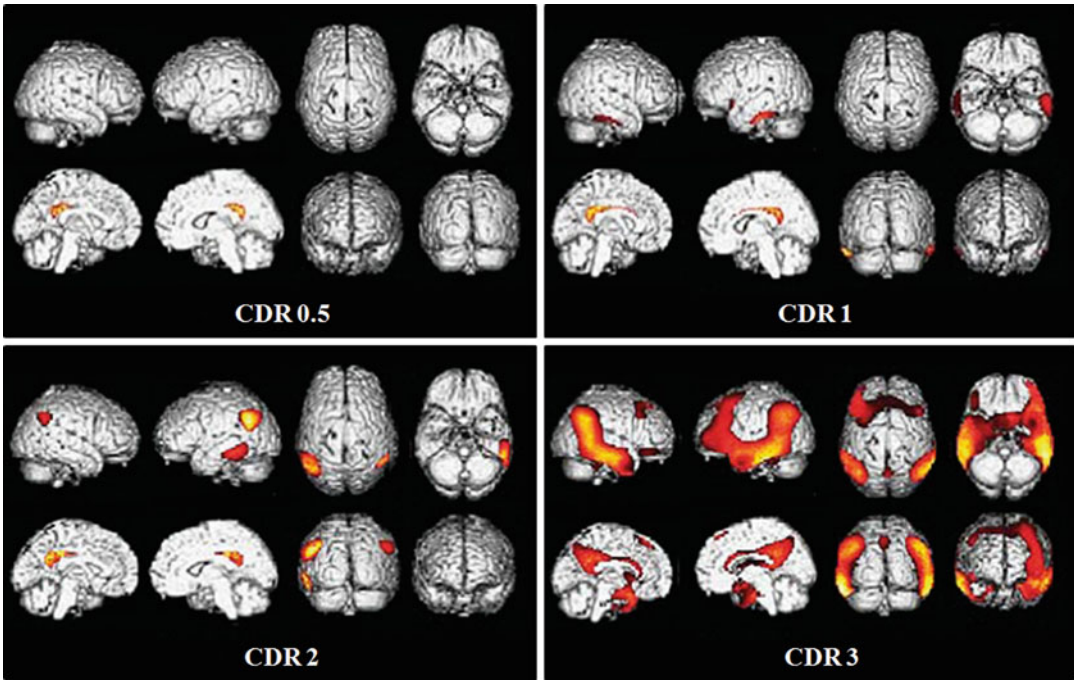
SPM results of ^{18}F -FDG PET images of AD. Brain glucose hypometabolism correlates with clinical dementia rating
